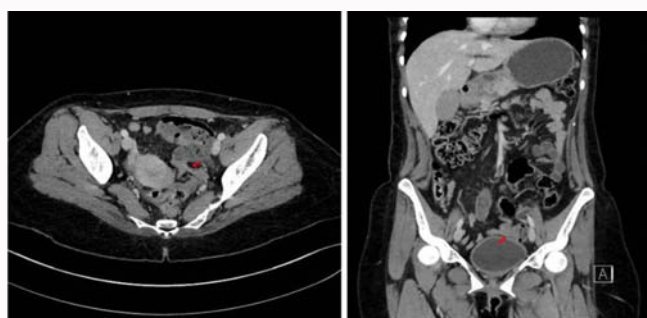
Abdominal and pelvic CT with contrast that shows the passage of small intestine and adipose tissue through the broad ligament with proximal dilatation of the small bowel and distal collapse.
